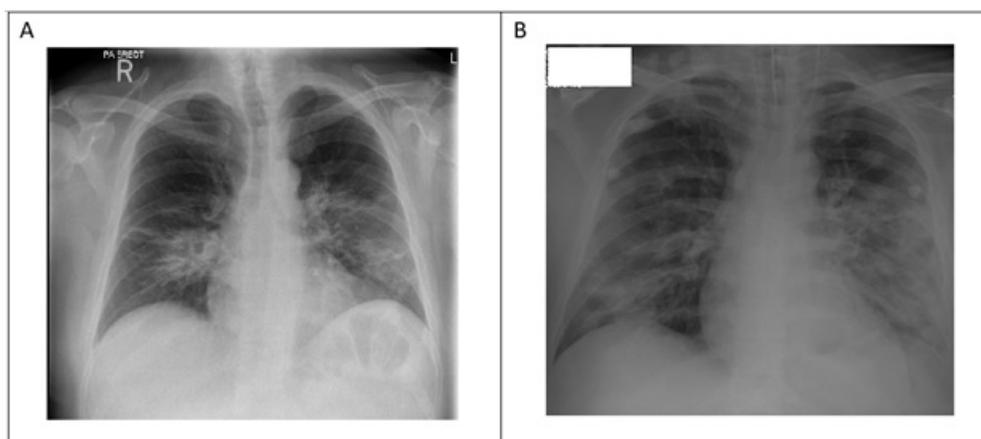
Patient's chest X-Ray images A) on admission to the ICU showing bilateral lower lung zones/perihilar infiltrates and patchy opacities and B) on day 16 showing ill-defined patchy and fluffy opacities, partially coalescing, within both lungs more in the left indicating massive parenchymal inflammatory infiltrates.
